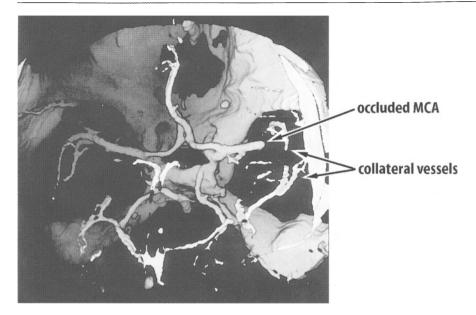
Three dimensional reconstruction of CT-angiography showing MCA occlusion and collateral blood flow
